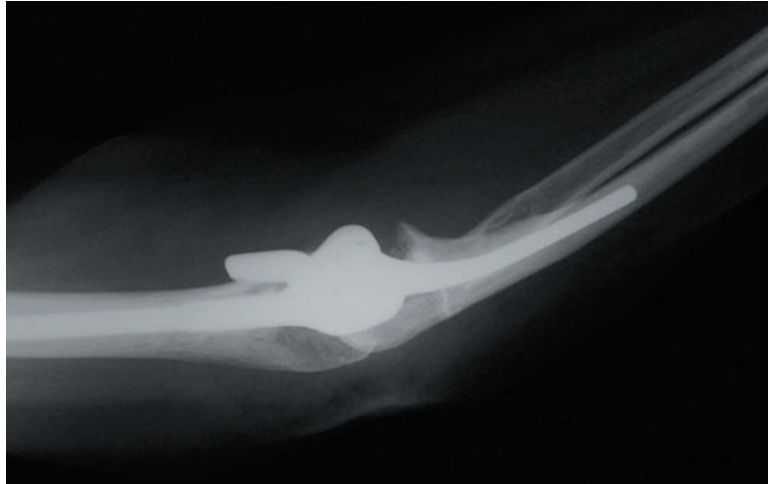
X-ray of elbow joint replacement
